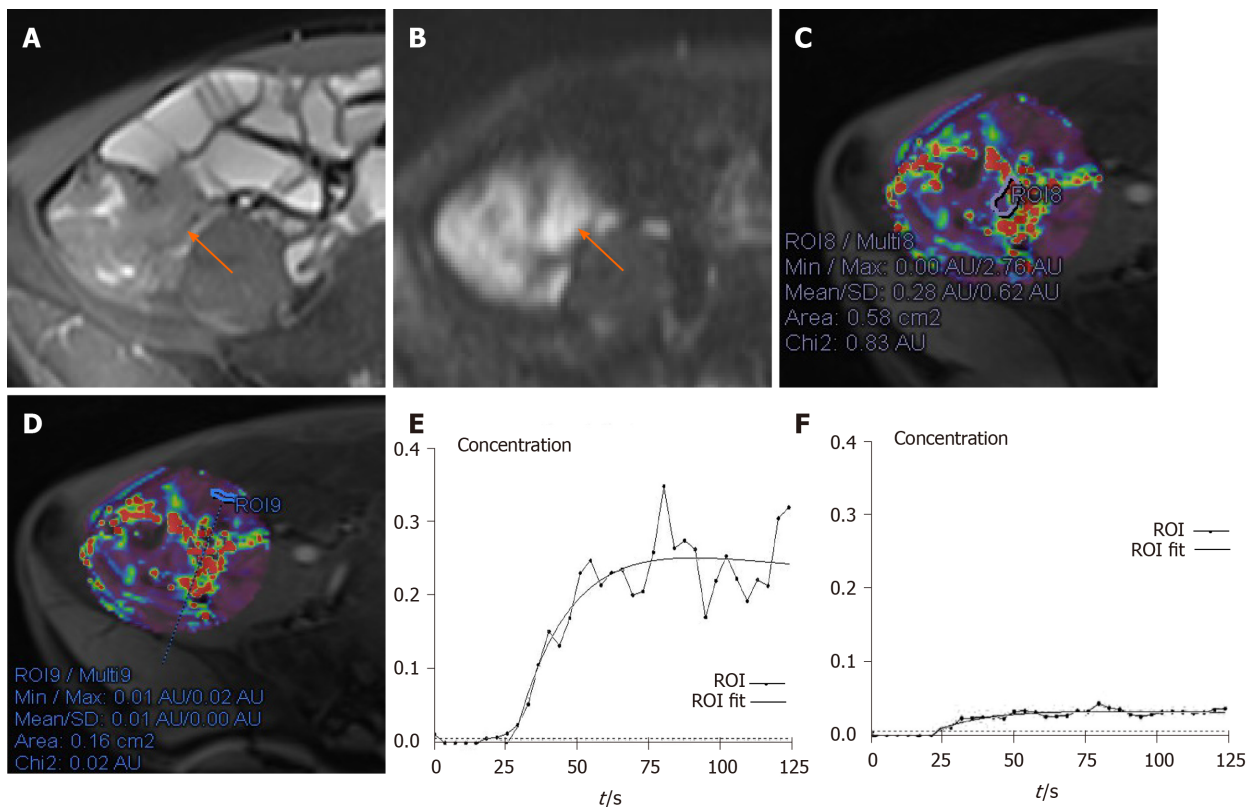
A 41-year-old male with moderate active Crohn's disease in the terminal ileum and a Crohn's Disease Activity Index of 267 and Crohn's Disease Endoscopic Index of Severity of 12. A: Terminal ileum demonstrates wall thickening and increased signal on axial T2-weighted image; B: Terminal ileum wall has a high signal. Axial diffusion-weighted imaging image ($b = 800 \text{ s/mm}^2$) demonstrates high signal (arrow) in the same bowel segment. Region of interest (ROI) for the inflammatory bowel wall shows that apparent diffusion coefficient = $1.11 \times 10^{-3} \text{ mm}^2/\text{s}$; C: ROI for the inflammatory bowel wall shows that $K^{\text{trans}} = 0.10 \text{ min}^{-1}$ ($K_{\text{ep}} = 0.87 \text{ min}^{-1}$, $V_e = 0.11$); D: In contrast, ROI of the normal appearing ileal loop shows that $K^{\text{trans}} = 0.01 \text{ min}^{-1}$ ($K_{\text{ep}} = 0.80 \text{ min}^{-1}$, $V_e = 0.02$); E: The contrast concentration curve of inflammatory bowel is plotted as ROI (line with circle) and fitted with the model (line); F: The contrast concentration curve of normal loop is plotted as ROI (line with circle) and fitted with the model (line). ROI: Region of interest.
